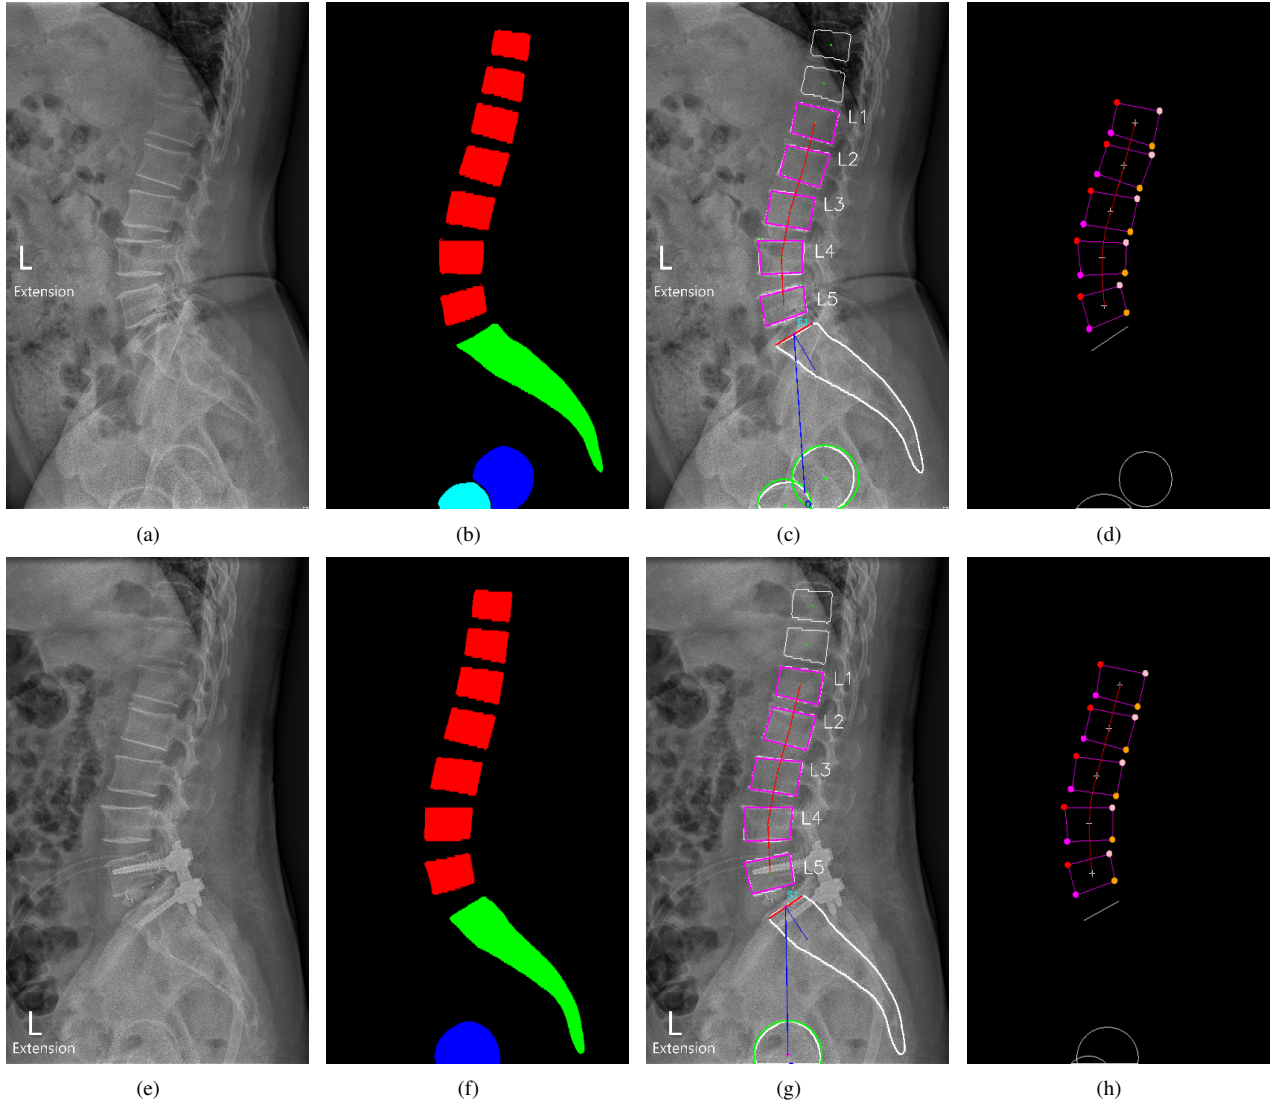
Our identification of lumbosacral spine and hip joints with our BiLuNet network on the challenging X-ray image. (a, e) are an input X-ray images before surgery and after surgery. (b, f) are semantic segmentation of the vertebrae, sacrum, left hip joint, and right hip joint, which is segmented with red, green, blue, and cyan color respectively. (c, g) are our results with the identified shape and location of these objects (L1, L2, L3, L4, L5, S1, hip axis). (d, h) are the annotated results of experts and doctors.
